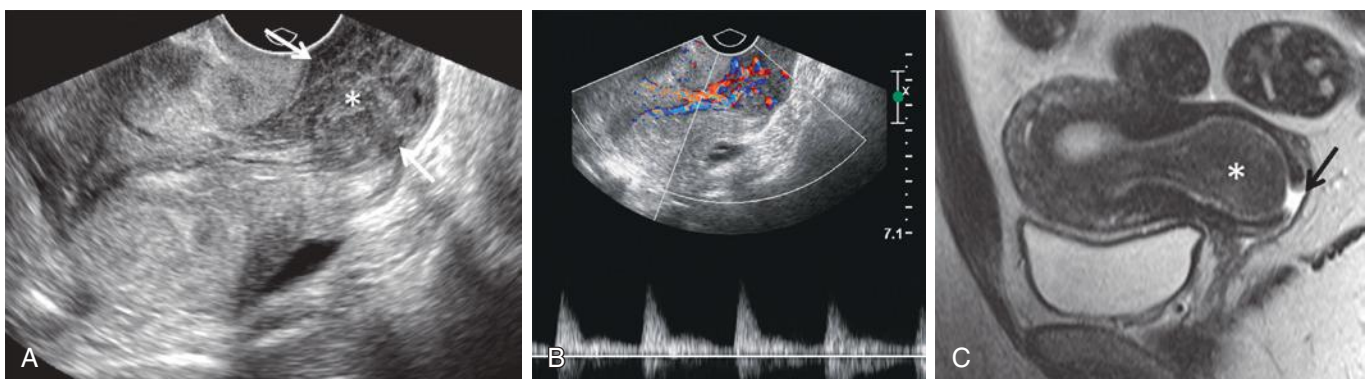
Prolapsing submucosal leiomyoma in patient with pelvic pain and vaginal bleeding. A, The prolapsing leiomyoma (asterisk) splays the cervix and extends through the endocervical canal into the upper vagina (arrows). B, Vascular pedicle with arterial flow is demonstrated with color and spectral duplex Doppler sonography. C, T2-weighted sagittal magnetic resonance imaging in another patient demonstrates a prolapsing leiomyoma (asterisk) splaying the cervix. Note high signal intensity fluid at the level of the open external cervical os (arrow).
